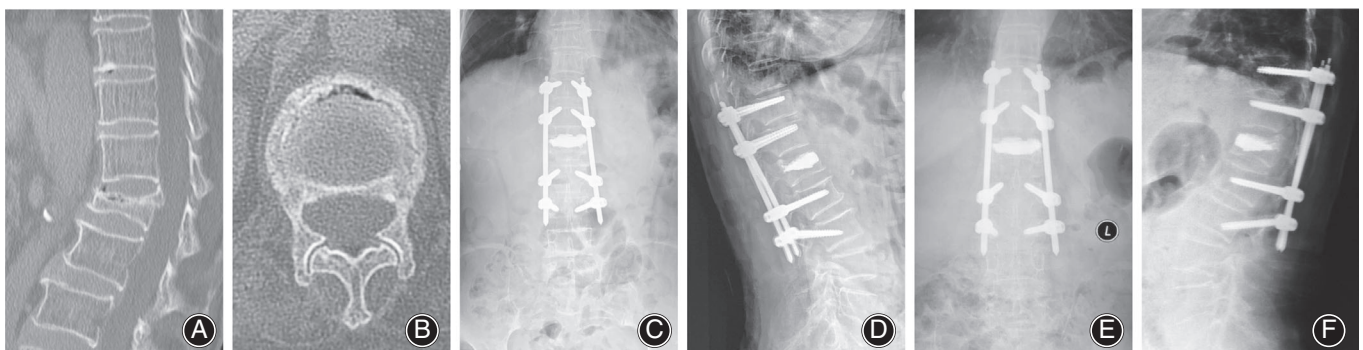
A 81-year-old female patient who underwent percutaneous fixation combined with vertebroplasty for L₁ Kümmell disease. (A, B) Preoperative CT scan showing L₁ fracture with IVC. (C, D) Postoperative X-ray showed fine bone cement position and Kümmell disease vertebral body height recovery. (E, F) final follow-up X-rays revealing good internal fixation and bone cement position.
